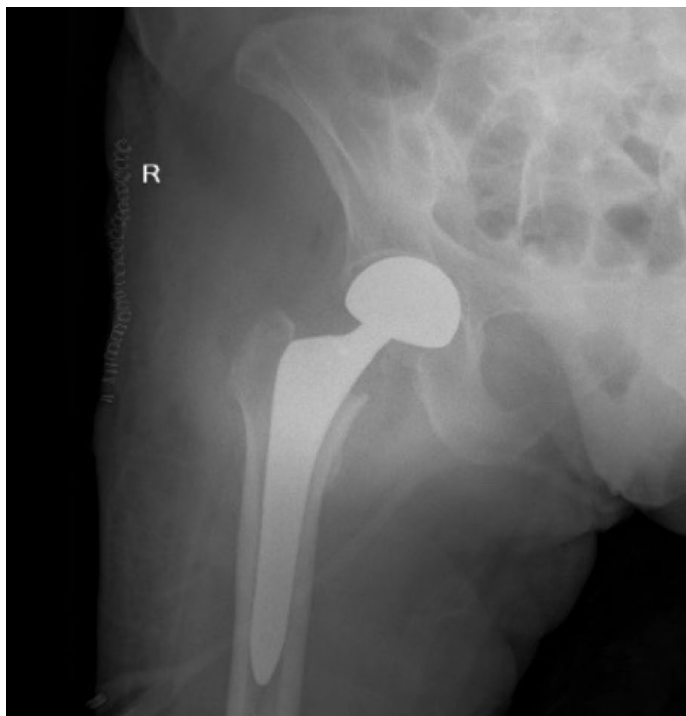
Postoperative anteroposterior (AP) radiograph of the right hip demonstrating a partial hip prosthesis.
